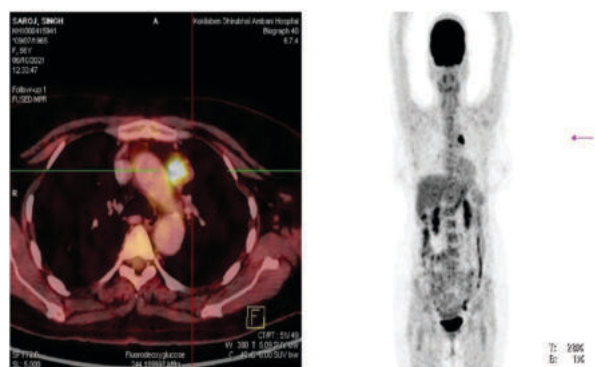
The follow up PET-CT showed increased FDG uptake in solitary prevascular lymph node only.
